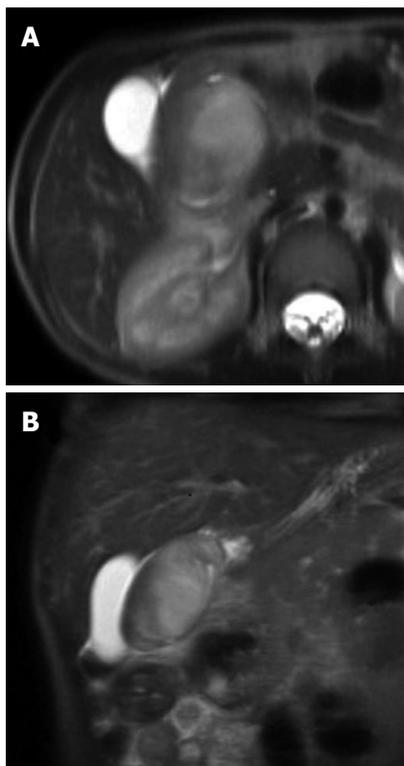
T2-weighted magnetic resonance image in axial (A) and coronal (B) scans, showing the solid mass arising from the duodenum.
